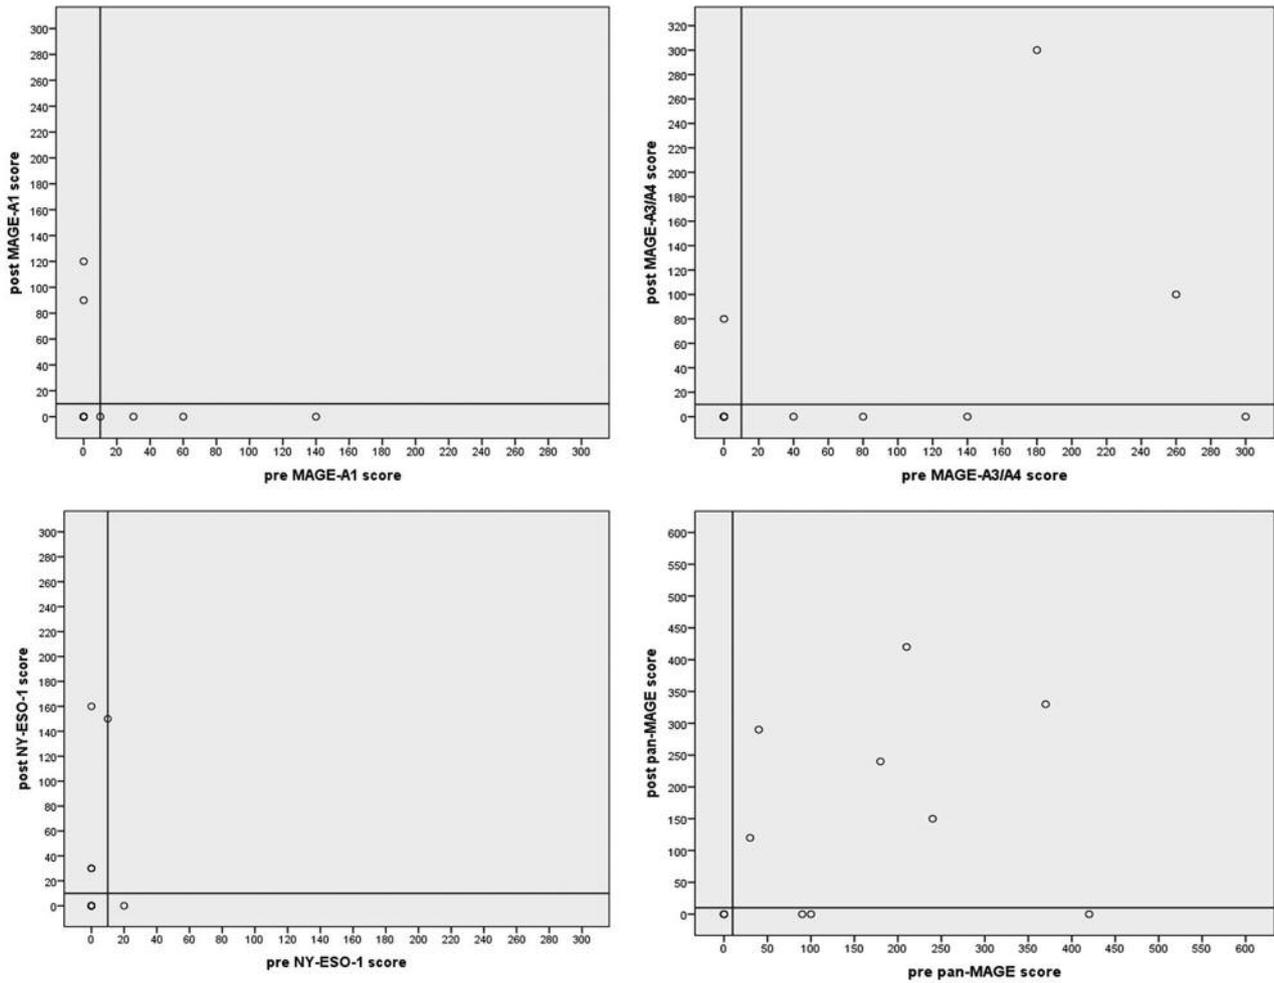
Expression sum-scores of all cancer/testis antigens (CTAs). The horizontal and vertical lines demonstrate the 10% mark separating positive and negative tumors. The upper left area shows patients with pre-PDT-negative and post-PDT-positive results, in the upper right area are double-positive results. The lower left area contains patients with a double negative expression and the lower right area with pre-PDT-positive and post-PDT-negative expression of the analyzed CTA. MAGE, Melanoma-associated antigen; NY-ESO-1, New York esophageal squamous cell carcinoma 1.
